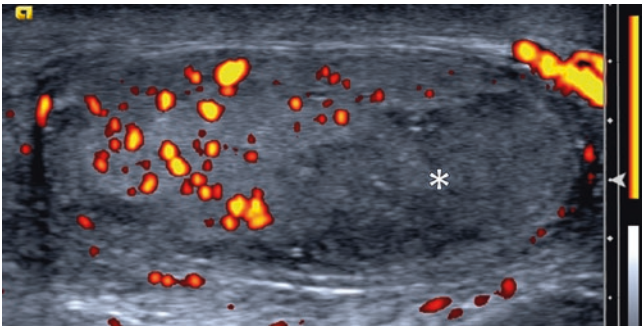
An 88-year-old with anastomotic leakage after rectal surgery, pelvic abscesses, sepsis, and painful scrotal swelling. (a) US of the scrotum shows a well-circumscribed, lobulated, heterogeneously hypoechoic mass (arrows) with (b) intense peripheral (arrow) but no central (asterisk) flow on Doppler US. The patient underwent orchiectomy, which confirmed the infectious etiology
